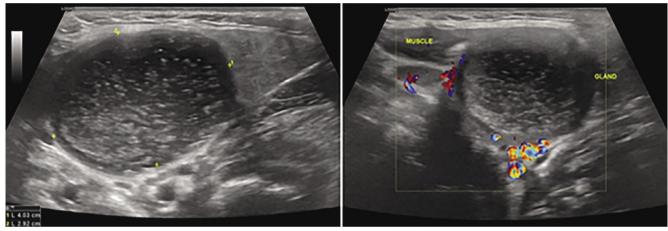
2nd cleft cyst: located in the submandibular region with thick mucous content of high echogenicity and without increased vascularity on color Doppler
